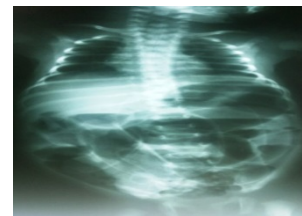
Abdominal X-rays shows extensive bowel dilatation.
